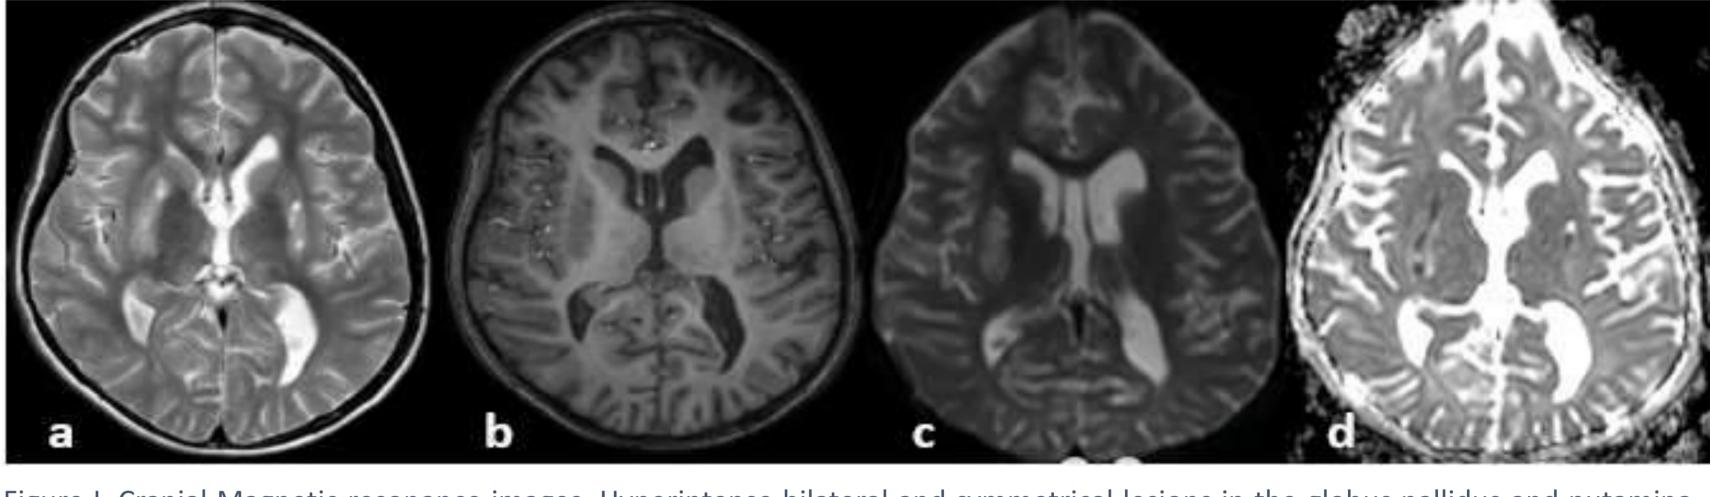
Cranial Magnetic resonance images. Hyperintense bilateral and symmetrical lesions in the globus pallidus and putamina, on T2 weighted images, hypointense on T1. a-axial T2, b-axial T1, c-axial DWI, d-axial ADC
